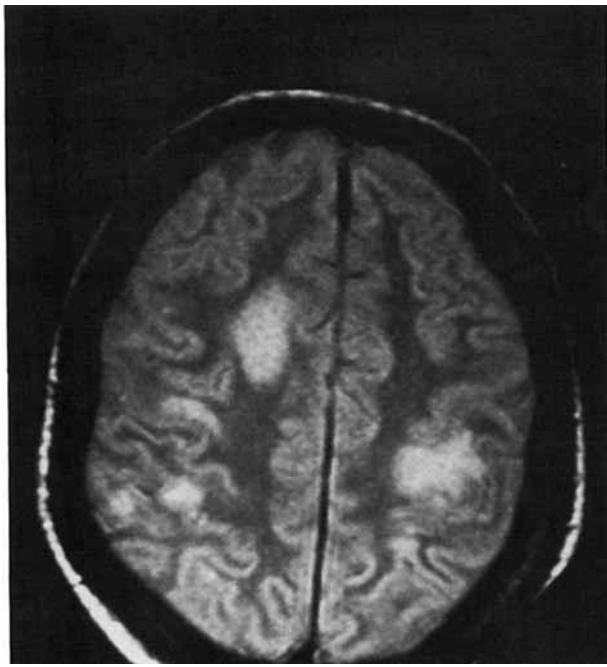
Proton-density head magnetic resonance imaging scan of Subject 1 demonstrates multiple discrete lesions in both hemispheres, primarily involving white matter, and extending to gray-white matter junctions.
